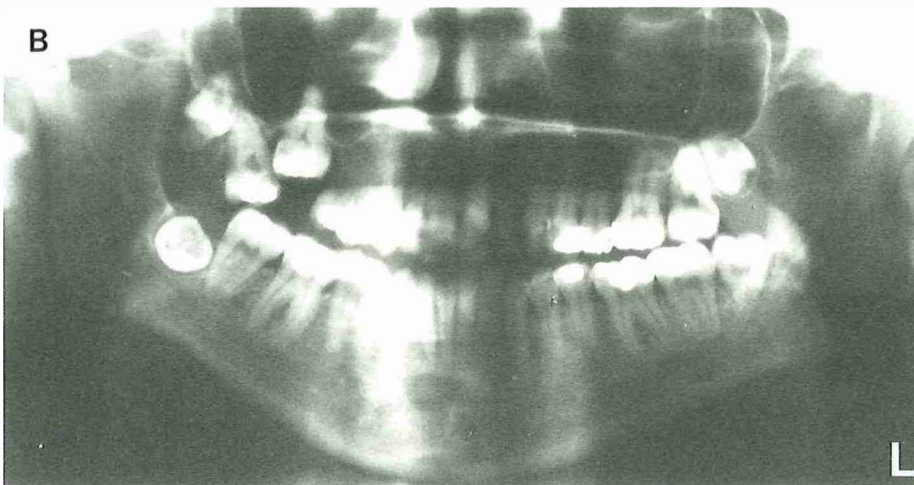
A Clinical view of the maxilla of a 27-year-old woman showing secondary retention of the first molar. B Orthopantomogram of the jaws of same patient
